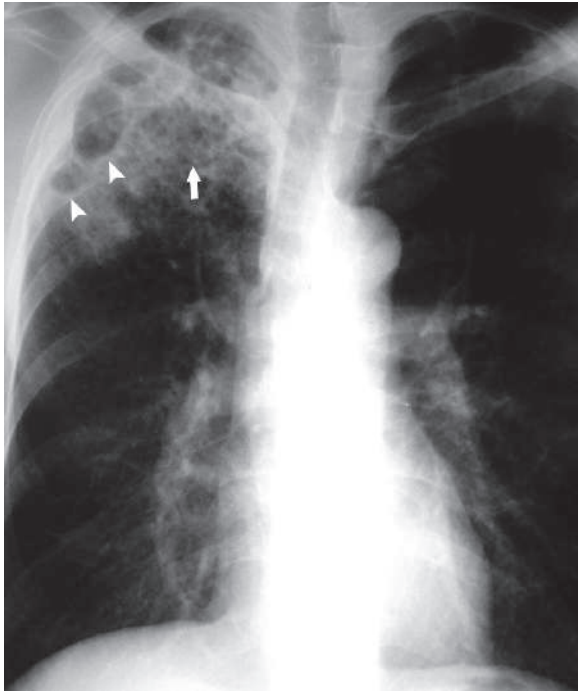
Posteroanterior plain chest radiograph of a patient with mycoplasma pneumoniae pneumonia shows right upper lobe fibrosis with honeycombing due to traction bronchiectasis (*arrow*) and paracatricial emphysema (*arrowheads*)
